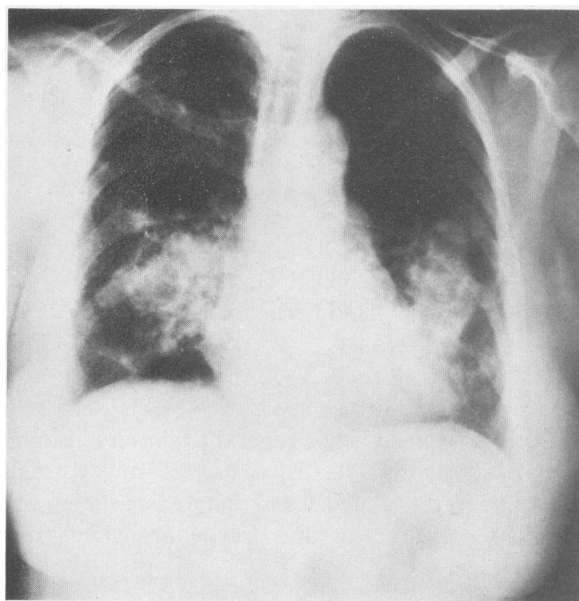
Photograph of a chest roentgenogram showing a diffuse reticulonodular infiltrate with conglomerate masses in both midlung zones.
